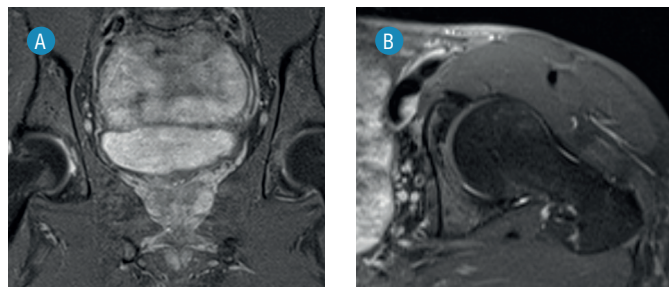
MRI of the hips of patient M., 23 years old, with aseptic osteonecrosis of the left femoral head, Ficat stage I, 12 months after treatment using regenerative interventional technologies (details in the text).
